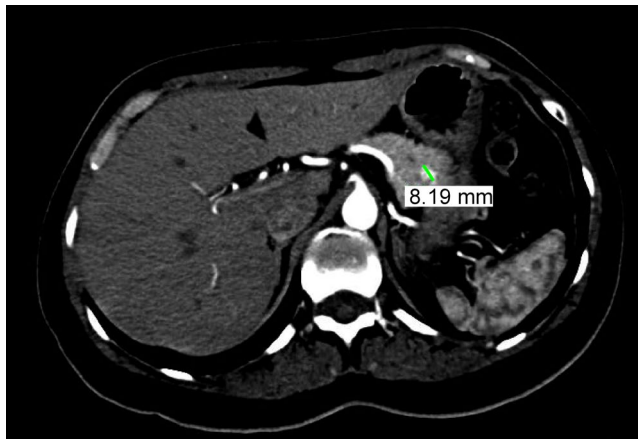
Abdominal CT scan showing a hypervascular neof ormation mass measuring 8 mm in the body of the pancreas. Intravenous contrast revealed an intense arterial enhancement which remained isodense in simple and delayed phases. The rest of the pancreas presented a preserved morphology. Based on the radiographic and clinical characteristics, a neuroendocrine tumor was considered
